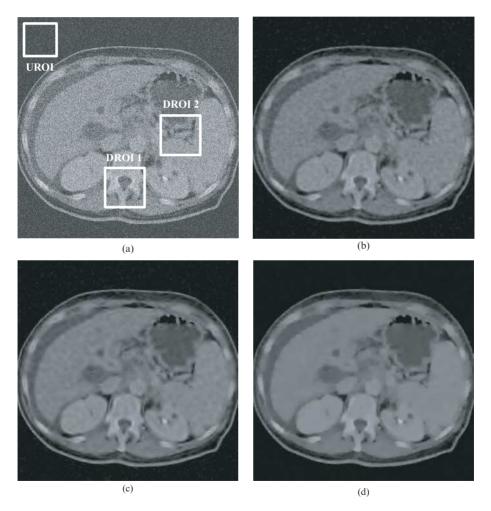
Experiments on MRI image *Liver*. The Desired Region Of Interest (DROI) and Undesired Region Of Interest (UROI) used to compute the MSR and CNR indexes (listed in Table 5) are highlighted. (a) The noisy image. (b) Estimated by the STH. (c) Estimated by the HTH. (d) Estimated by the presented MPTH.
